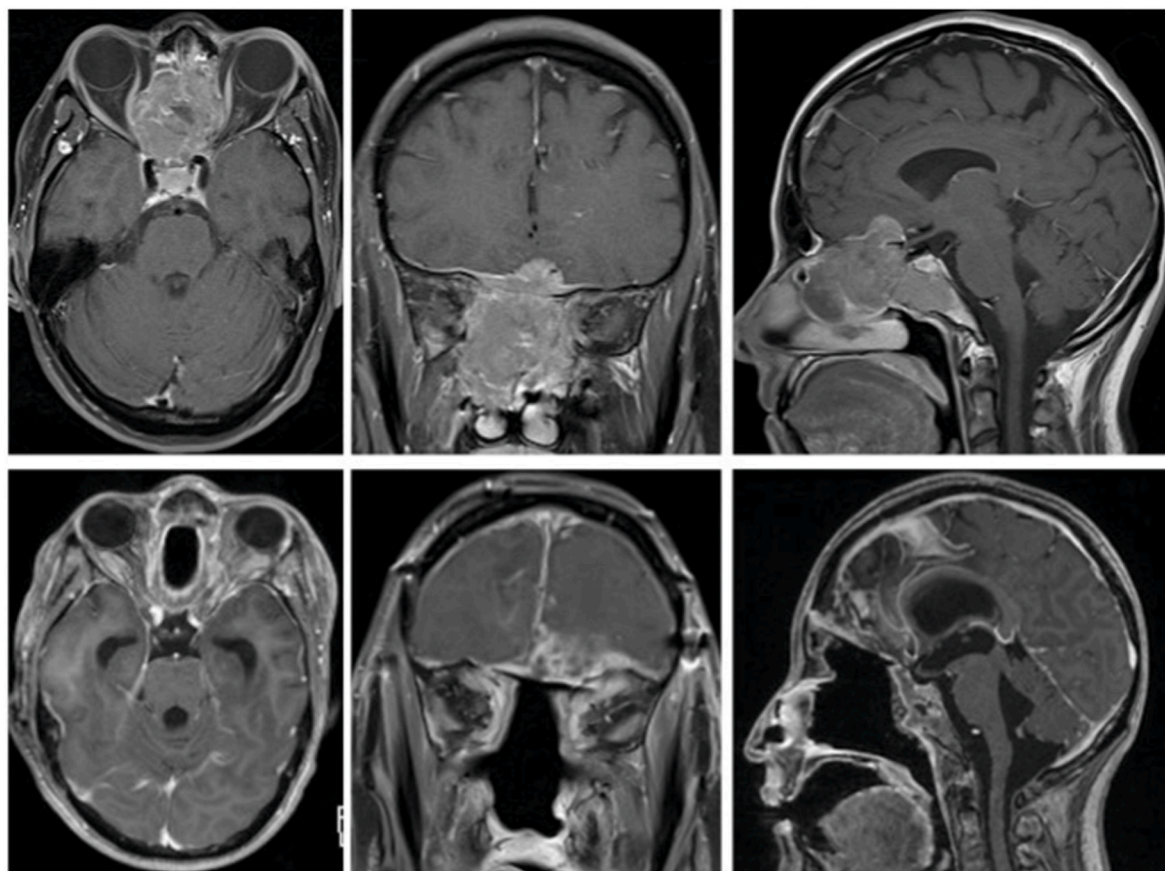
Pre- (top row) and postoperative (bottom row) MRI scans (transversal, coronal, axial) with Gadolinium-DTPA contrast agent depicting the sinonasal and frontobasal esthesioneuroblastoma involving the middle cranial fossa (anterior clinoid process, chiasmatic groove) of patient No. 10. Residual tumor mass can be seen in the left superior part of the periorbita.
